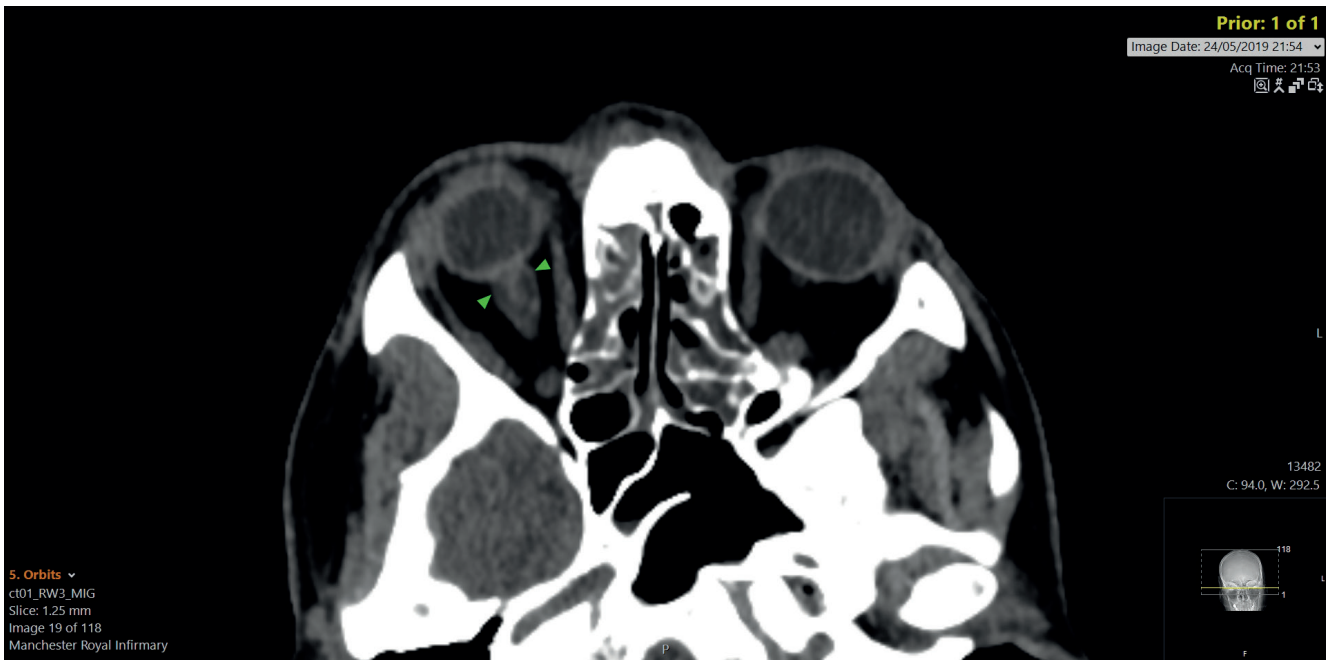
CT head showing dilatation of optic nerve sheath.
